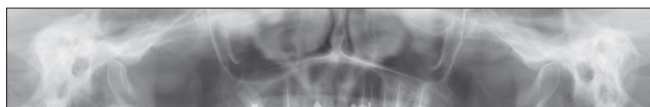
An orthopantomogram which shows asymmetry as crooked finger (type IV) - diamond (type II) for the right and left condyle
